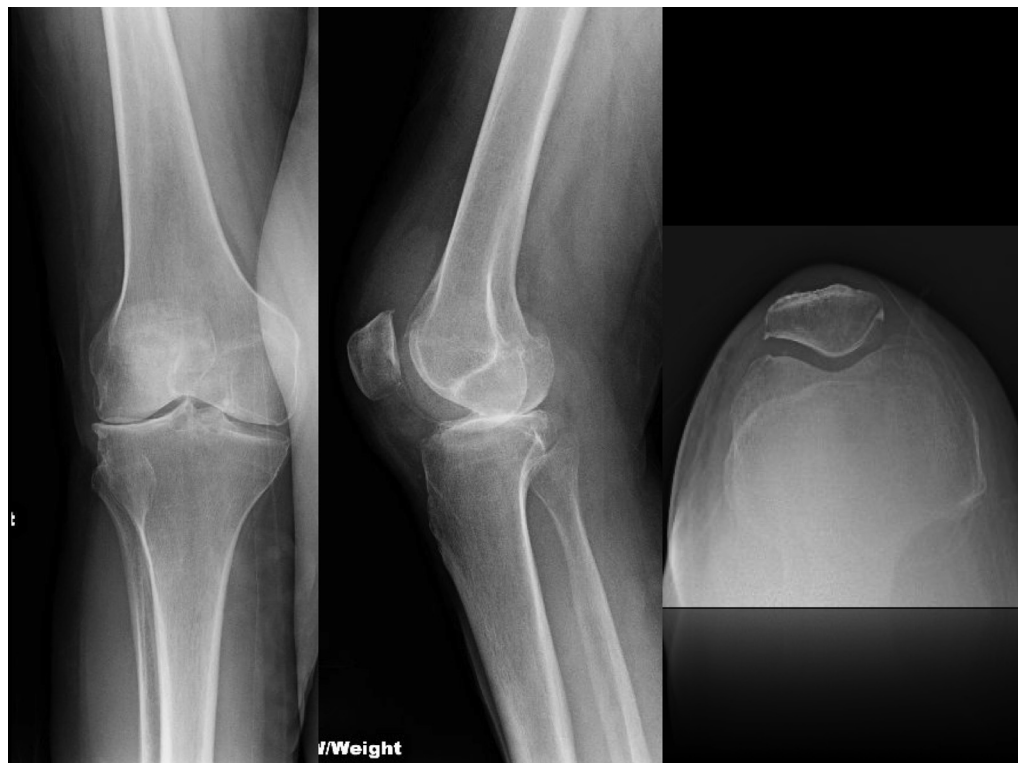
Preoperative radiographs. Preoperative anteroposterior (AP), lateral, and merchant weight bearing views of the right knee showing severe tricompartmental arthritis.
